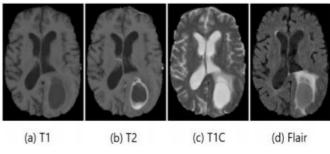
MRI scans with four modalities [25]
